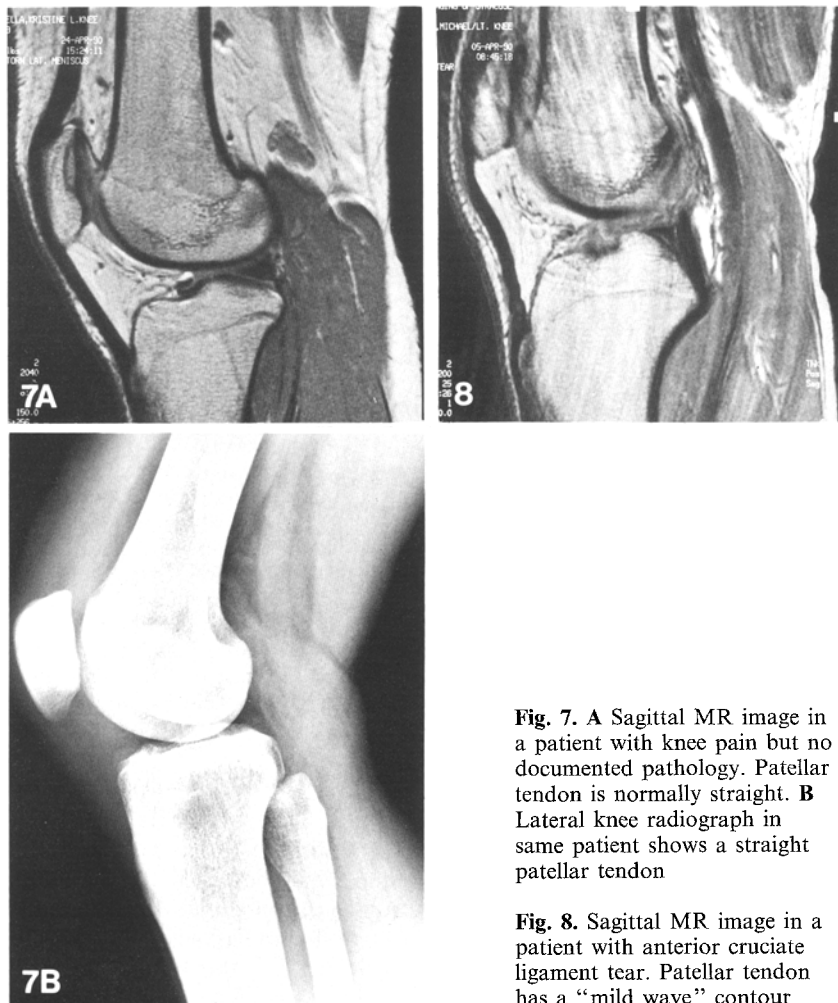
A Sagittal MR image in a patient with knee pain but no documented pathology. Patellar tendon is normally straight. B Lateral knee radiograph in same patient shows a straight patellar tendon
